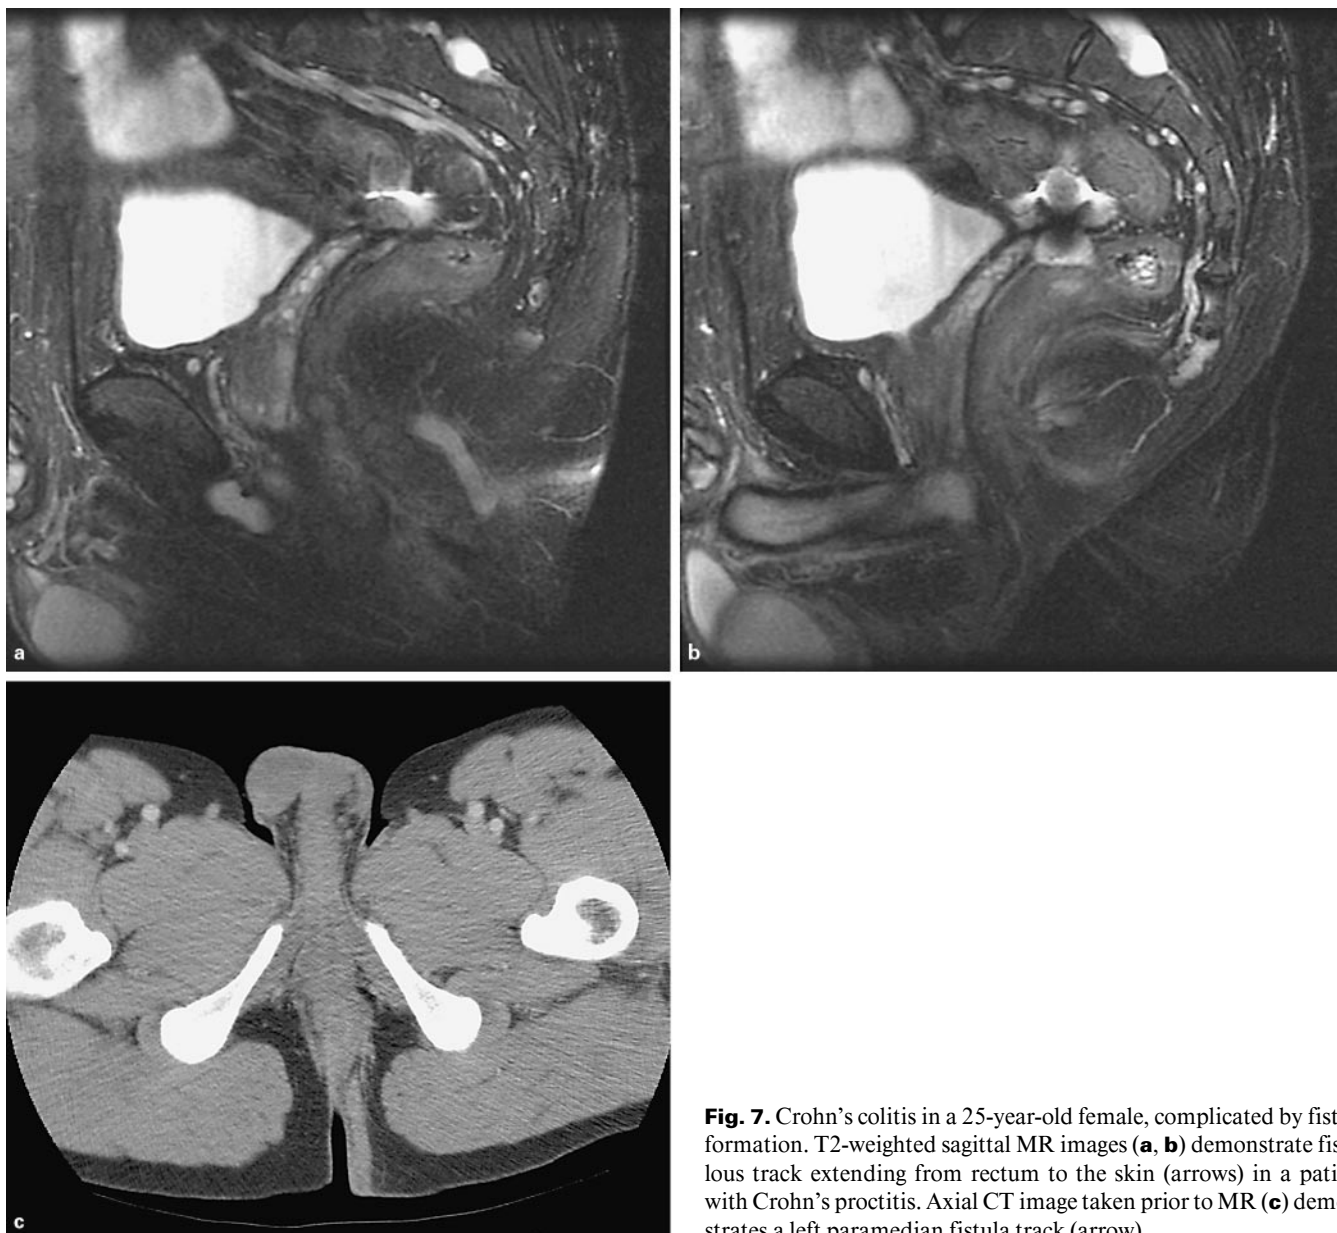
Crohn's colitis in a 25-year-old female, complicated by fistula formation. T2-weighted sagittal MR images (a, b) demonstrate fistulous track extending from rectum to the skin (arrows) in a patient with Crohn's proctitis. Axial CT image taken prior to MR (c) demonstrates a left paramedian fistula track (arrow).
